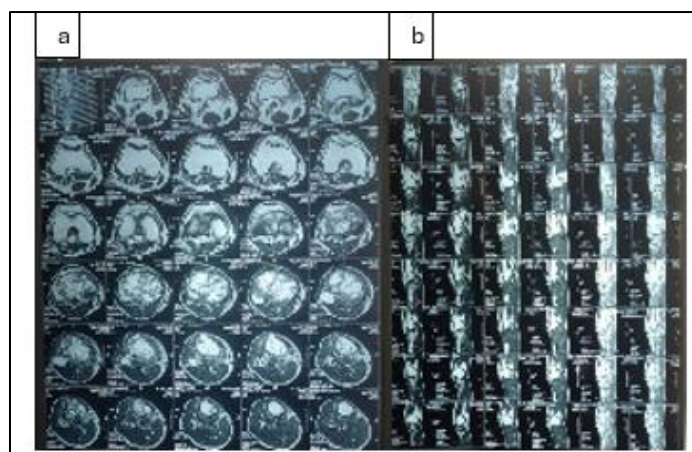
Figure 3ab MRI of the Right Proximal Tibia
